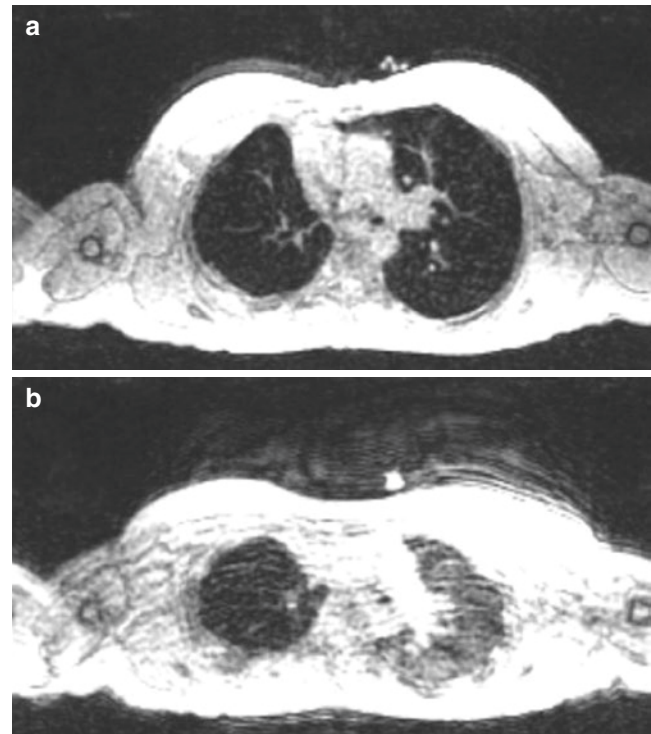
A 11-year-old girl with pulmonary hypoplasia. (a) Axial 3D SPGR MR image obtained at end-inspiration demonstrates a smaller right lung compared to the left. (b) Axial 3D SPGR MR image obtained at end-inspiration shows a diffuse hypointensity of the right hypoplastic lung due to air trapping
